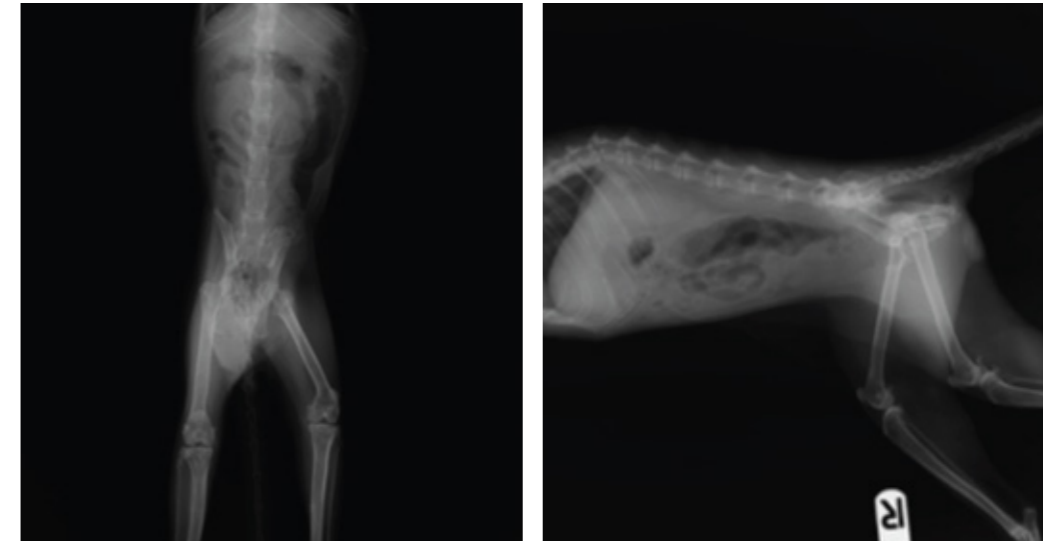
Radiographic image of week 32
